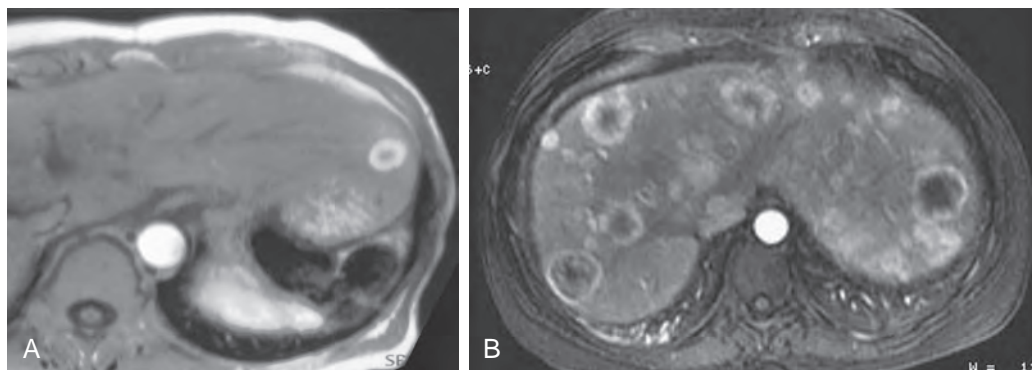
Liver metastases: ring enhancement on MRI. There are complete rings of lesion enhancement seen in this patient with breast cancer and a solitary metastasis in the left lobe (A) and in a different patient with multiple carcinoid metastases (B).
